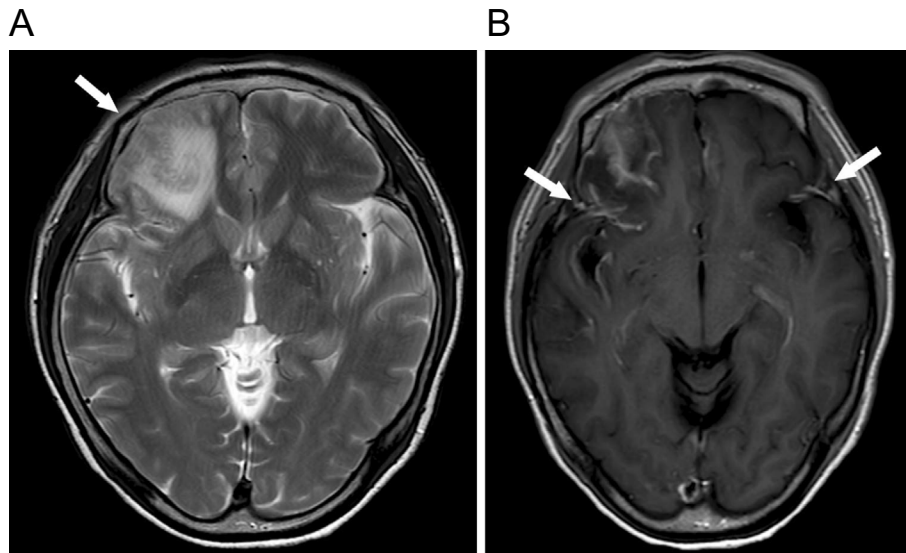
Brain magnetic resonance imaging (MRI). (A) T2-weighted brain MRI revealed edematous cerebral parenchyma of the right frontal lobe (arrow). Parenchymal involvement was noticeably absent. (B) Contrast-enhanced brain MRI showed partial enhancement around the right to left cerebral leptomeninges (arrow).
